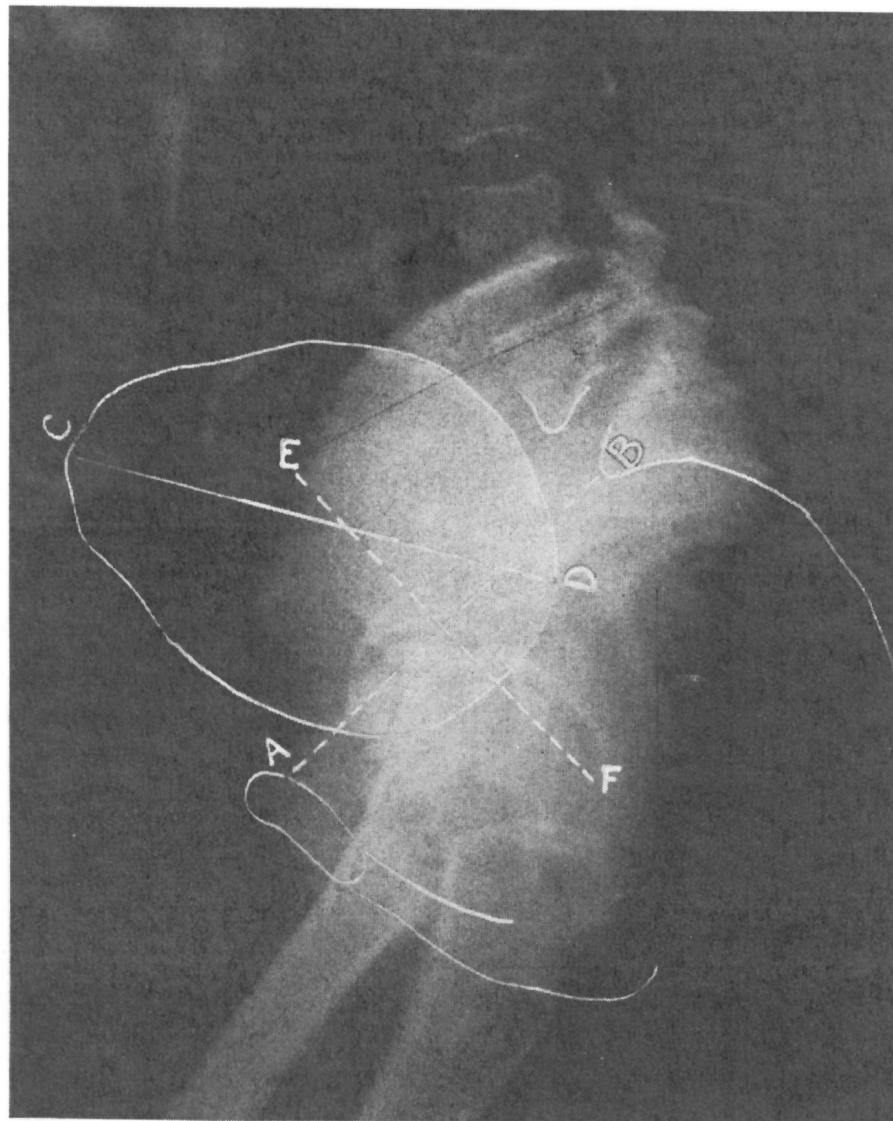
Lateral roentgenogram early in labor. *A. B.*, First plane of inlet and true conjugate diameter. *C. D.*, Long axis of fetal head. *E. F.*, Perpendicular to inlet through midpoint of true conjugate diameter. Extreme anterior parietal position, so rare in this degree as to be considered an obstetrical curiosity. Note relationship of *C. D.* to *E. F.* and *A. B.*
